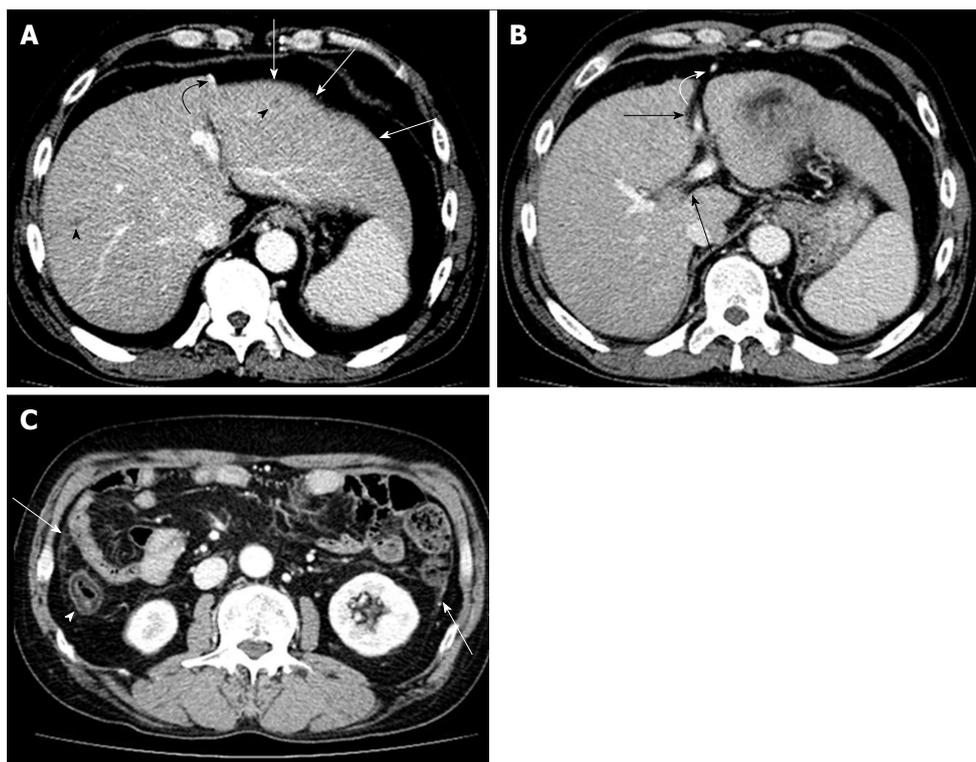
Contrast enhanced computed tomography portal phase images of the patient with liver cirrhosis due to chronic hepatitis B. A: Liver shows surface undulation (arrows). Two small low attenuated nodules are seen in both hepatic lobes suggesting regenerative nodules (arrow heads). Recanalized paraumbilical vein and paraesophageal varix are noted (curved arrow); B: Recanalization of paraumbilical vein (curved arrow) represents portal hypertension. Widening of hepatic fissure and porta hepatis is seen (black arrows); C: Ascending colon presents edematous wall thickening caused by congestion due to portal hypertension or hypoalbuminemic edema (curved arrow). Diffuse peritoneal thickening is also noted (arrows).
